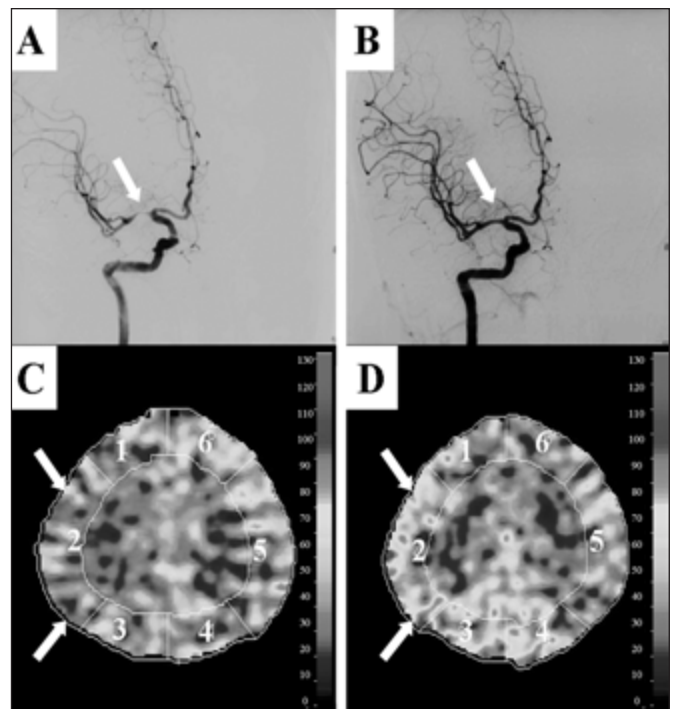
The manifestations of DSA and Xe-CT. A. Before stenting, DSA showed a severe stenosis (>70%) in the M1 segment of the right MCA. B. After stenting, DSA showed complete revascularization in the right MCA. C. Before stenting, CBF in the territorial cortex of the stenosed MCA as revealed by Xe-CT was significantly lower than that in the contralateral corresponding region. D. After stenting, Xe-CT revealed that CBF in the territory of the lesional MCA was markedly increased (an 87% increase of CBF in the right cortex as compared with that before stenting).
